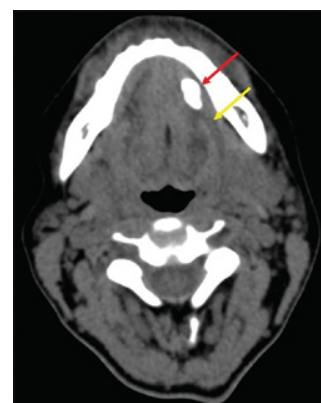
Sialolithiasis-CT. Axial CT image demonstrates a submandibular duct sialolith (red arrow) with dilated proximal duct (yellow arrow)
